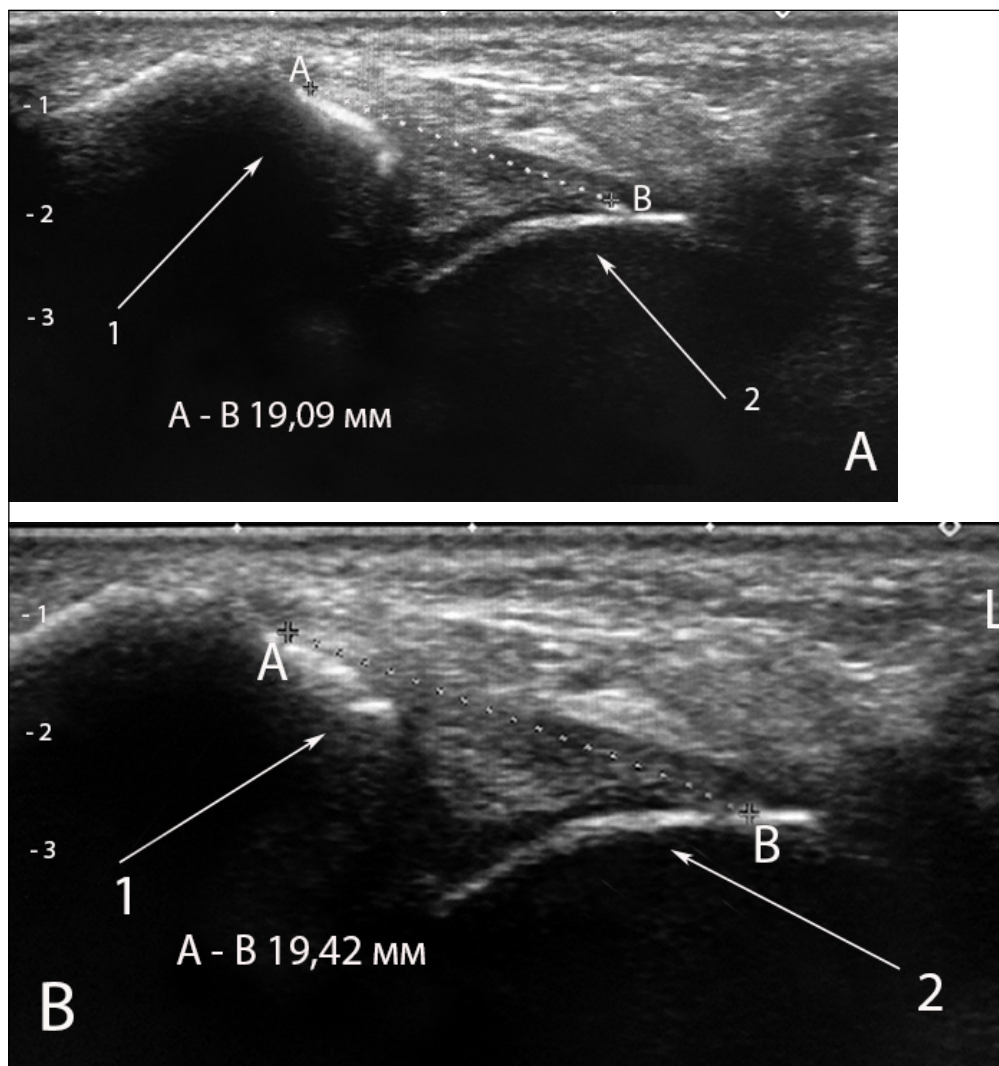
Length measurement of the anterior talo-fibular ligament (ATFL) in a neutral position during sonography in a control patient. A. Dimensions of the anterior talo-fibular ligament in a neutral position in a patient of the control group (A-B measurement points of the anterior talo-fibular ligament. 1 - fibula; 2 - talus). B. Dimensions of the anterior talo-fibular ligament during inversion loading in a patient of the control group (A-B measurement points of the anterior talo-fibular ligament. 1 - fibula; 2 - talus)
